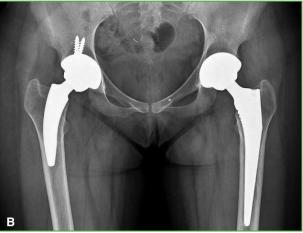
A. Immediate postoperative AP X-ray of the left hip of a 21-year-old patient (case 6) with idiopathic chondrolysis of the hip who suffered cortical perforation after bilateral sequential hip replacement. B. AP X-ray of both hips, 5 years after revision surgery. The modified Harris score was 95 for each hip.
